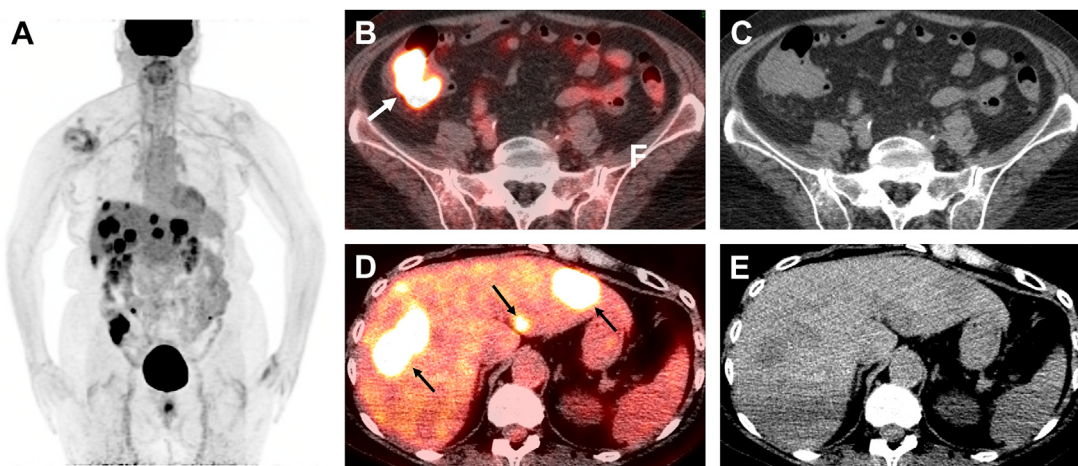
A 78-year-old-woman with adenocarcinoma of the cecum. ^{18}F -FDG PET/CT maximum intensity projection image (A) and trans-axial fused PET/CT and CT images show (B and C) the hypermetabolic primary soft tissue mass at the cecum (*white arrow*) and (D and E) multiple hypermetabolic hypoattenuating lesions in the liver (*black arrows*) that were biopsy proven as metastases from the colorectal primary.
